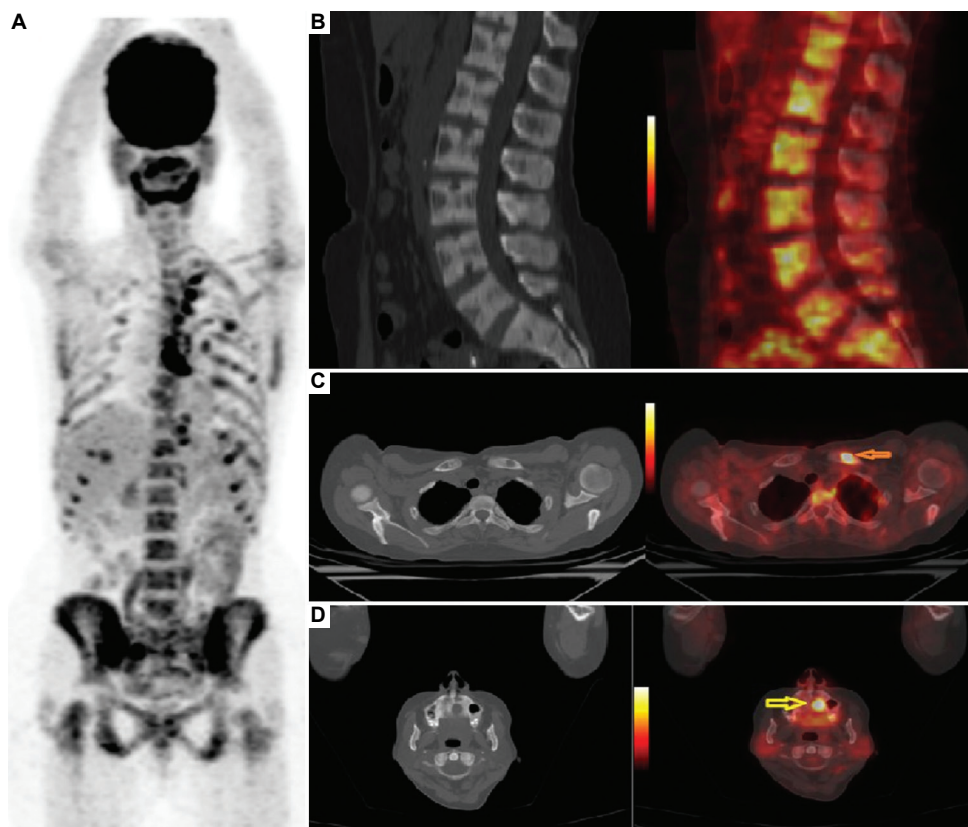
Hypermetabolic uptake in the spine, chondrocostal regions, and lower jaw. (A) 3D Maximum Intensity Projection (MIP) image show heterogeneous and diffuse hypermetabolism throughout the axial skeleton, particularly intense lower mandibular hypermetabolism and staggered, symmetrical hypermetabolic foci in the right and left chondrocostal joints, presumably metabolic in origin, related to the patient’s known chronic hemodialysis state. (B) Sagittal CT and PET/CT fusion images of the lumbar spine show multiple hypermetabolic lacunar foci corresponding to brown tumors. (C) CT and PET/CT fusion images show a rounded, hypermetabolic lytic lesion with regular contours in the inner third of the left clavicle (orange arrow). (D) CT and PET/CT fusion images show a hypermetabolic lower mandibular lacuna (yellow arrow). (B-D) Images corresponding to brown tumors. Abbreviation: PET/CT: Positron emission tomography/computed tomography.
